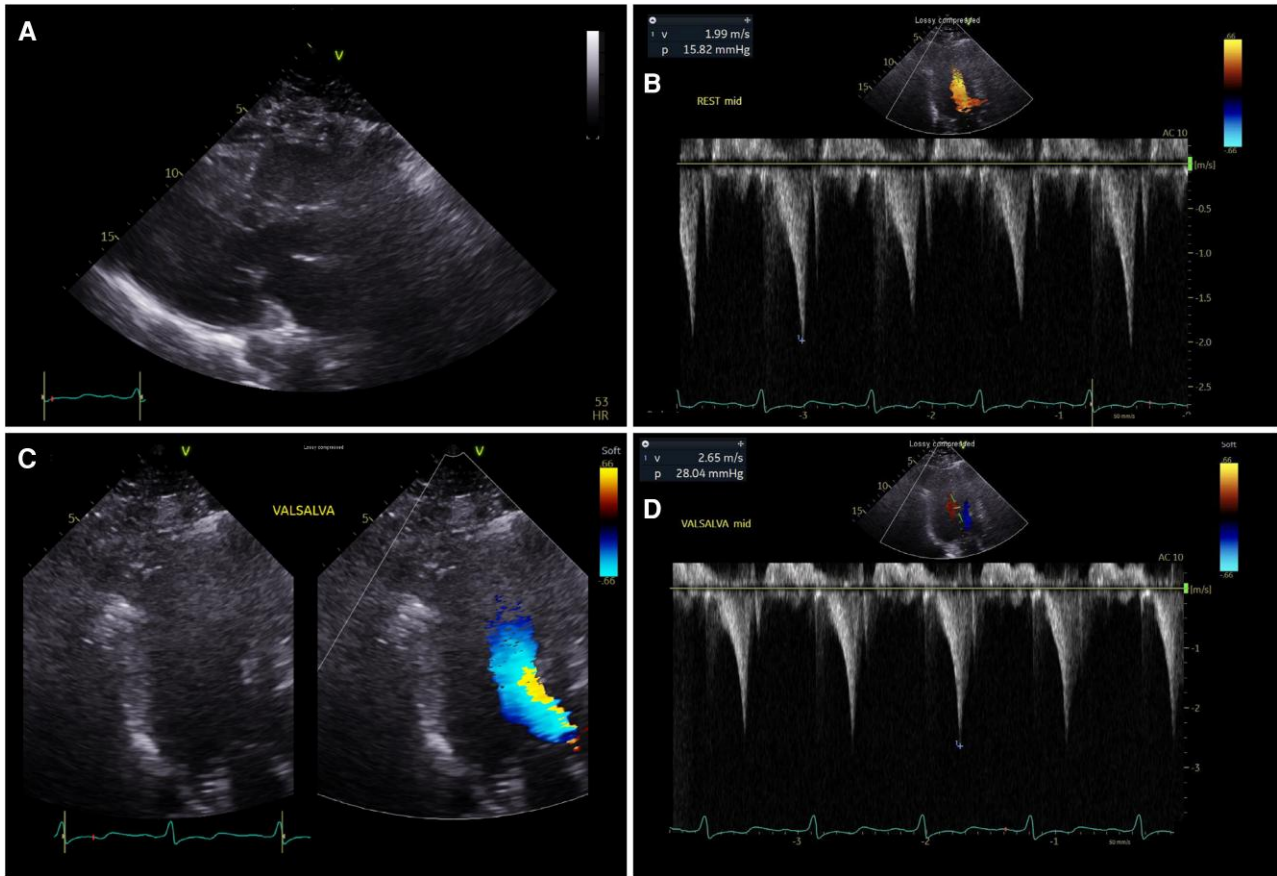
Follow-up echocardiography after re-initiation of lower-dose mavacamten. (A) Parasternal view showing preserved biventricular systolic function on mavacamten 5 mg and bisoprolol 3.75 mg. (B) Resting left ventricular outflow tract gradient measured of 16 mmHg. (C) Apical view showing reduced systolic cavitation with decreased left ventricular outflow tract flow acceleration on colour Doppler. (D) Provoked left ventricular outflow tract gradient of 28 mmHg during Valsalva manoeuvre, demonstrating the absence of haemodynamically significant obstruction. LVOT, left ventricular outflow tract.
